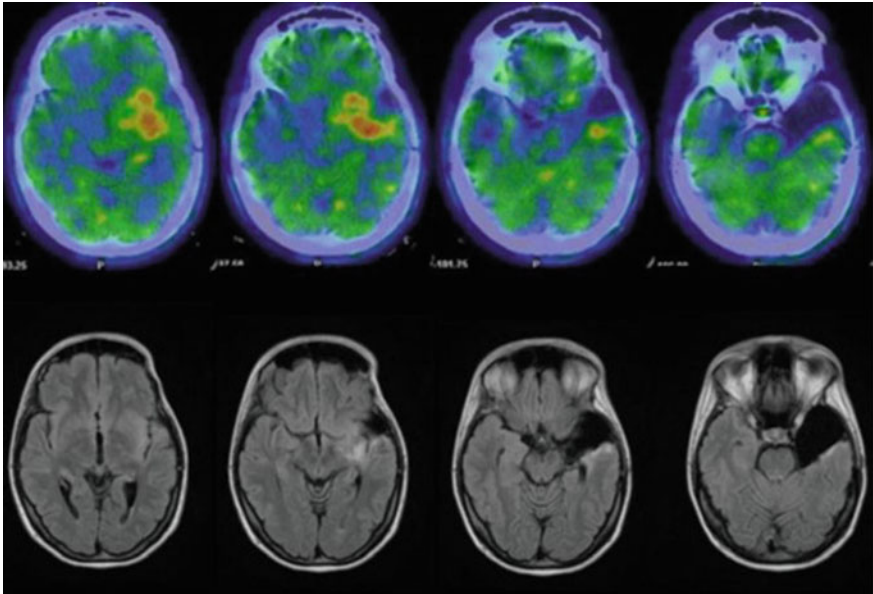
Transversal images of ^{11}C -Methionine PET/CT referred to the corresponding T1 weighted MRI; (upper study) perilesional recurrence at the level of surgical crater, both at the MRI (inferior views) and Methionine-PET (superior views)
